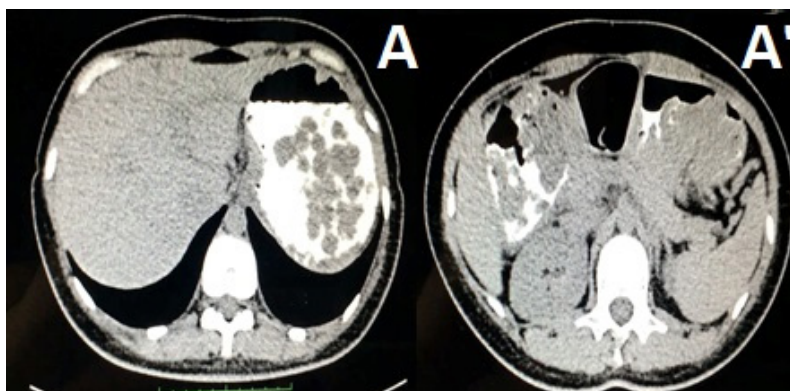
CT of the abdomen with oral contrast, showing large coralliform lesion of 16.3 x 10.2 x 5.4cm in the stomach (A) and in the first duodenal part (A')
